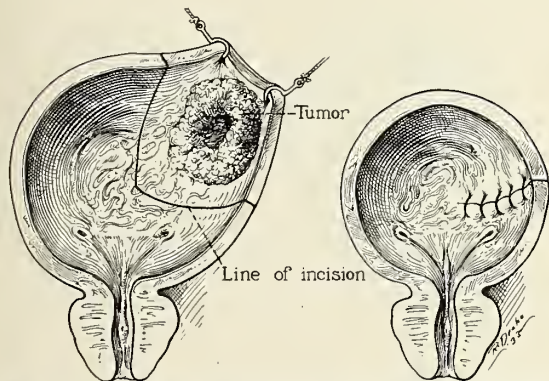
Patient aged fifty-six years. Squamous cell epithelioma, graded 4. Dysuria, hematuria and cloudy urine had been present for one year. Segmental resection was done. Roentgen treatment for four hours after operation. Condition good at time of dismissal.
